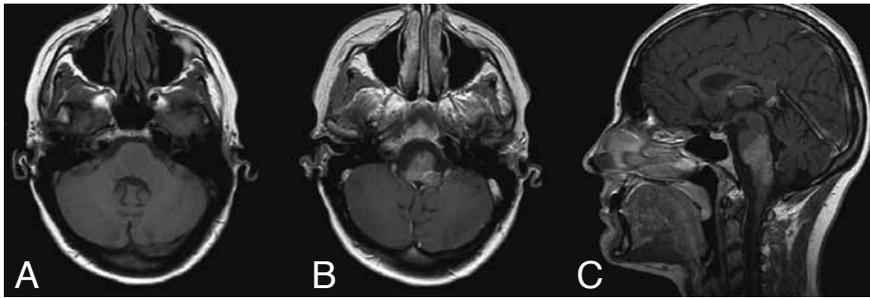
A. Axial T1-weighted image: the lesion is hardly visible. B. Axial enhanced T1-weighted image: there is moderate enhancement of the lesion with brush-like borders. A strongly enhancing tubular structures crosses the lesion corresponding to a DVA. C. Sagittal enhanced T1-weighted image: Diffuse and moderate enhancement with a craniocaudal extension over 4 cm.
